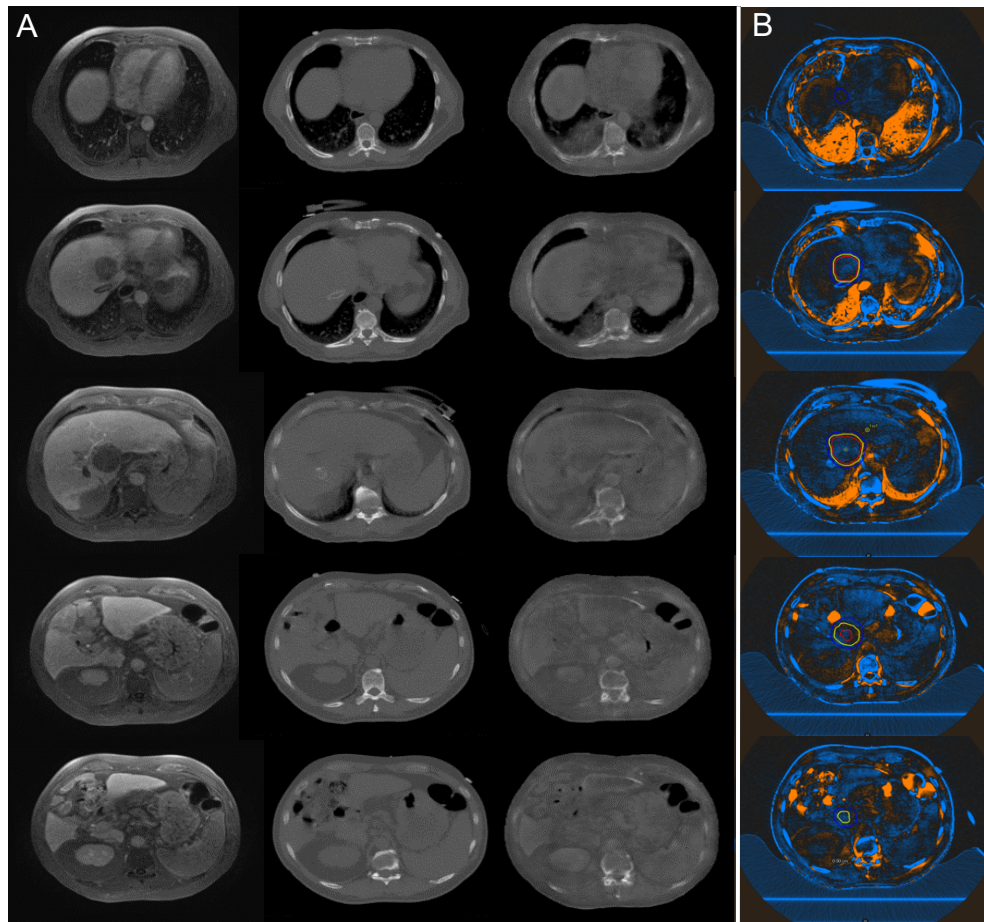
(A) Axial slices of MRI (left), CT (middle) and sCT (right) for a liver cancer patient. Note that the bellows to assess the breathing trace is visible on CT. (B) Blue indicates areas where the CT HU values are higher than in the sCT, while orange indicates areas where the sCT HU values are higher than in the CT with a saturation threshold set at ± 300 HU. The structure contours are shown as PTV (blue) ITV (yellow), and GTV (red).
